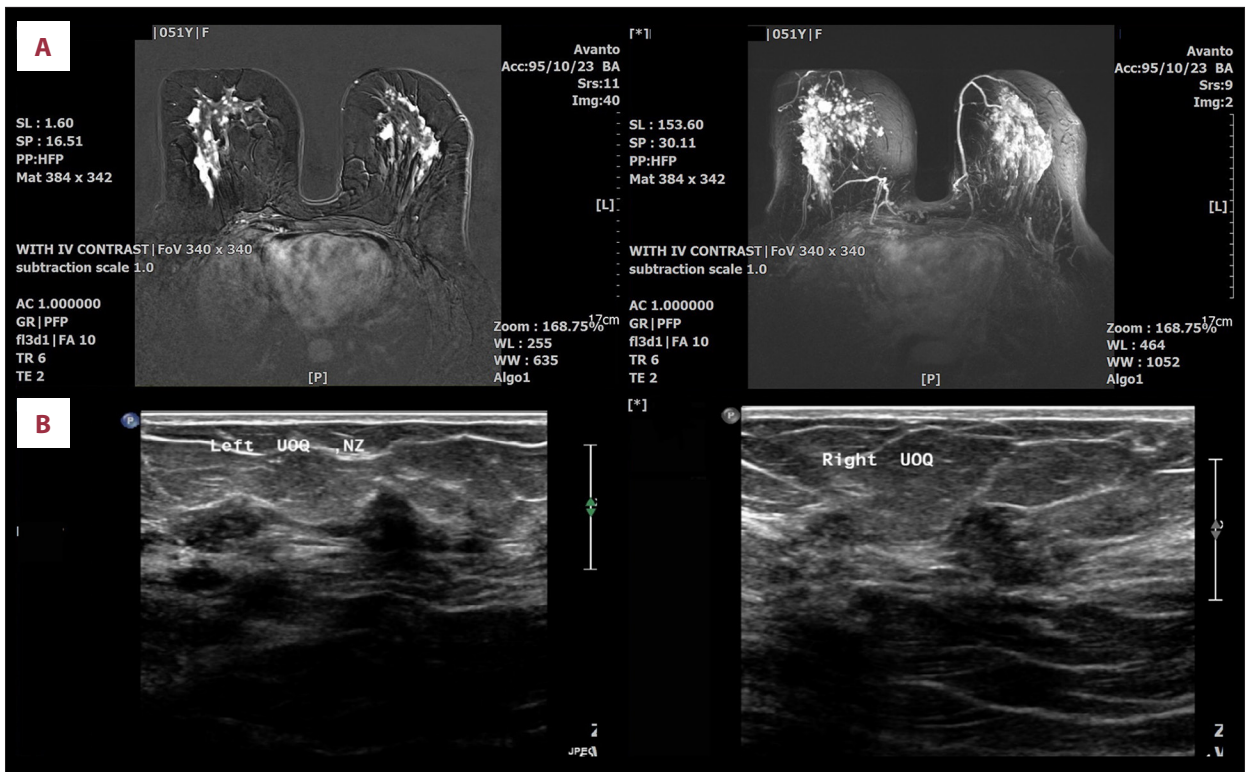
(A) Magnetic resonance mammography (MRM): bilateral multiple small enhancing masses of different sizes are seen. (B) Breast ultrasound: bilateral tissue distortion and indistinct hypochoic small masses are shown (BIRADS: IVC).
